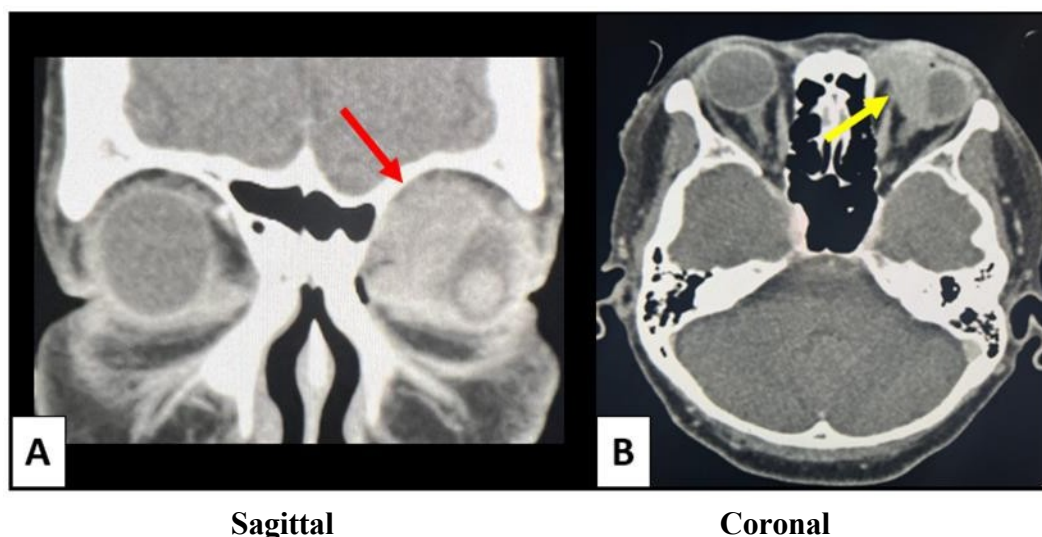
CT scan of the orbits with contrast, lobulated enhancing mass 3.4 x 1.9 x 2.9 cm of the right orbit with thickening obscuring the fascial plane.
